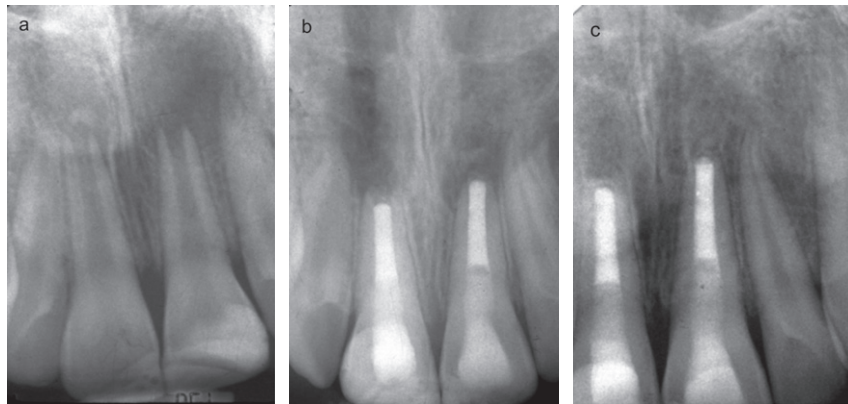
(a) Pre-operative radiograph reveals the presence of periapical lesions and open apices in the maxillary central incisors. (b) The teeth were accessed, cleaned, and filled with MTA apical plugs after the initial use of calcium hydroxide for 2 weeks. (c) A post-operative radiograph after 22 months shows resolution of the periapical lesions and development of apical hard tissue in these teeth.
